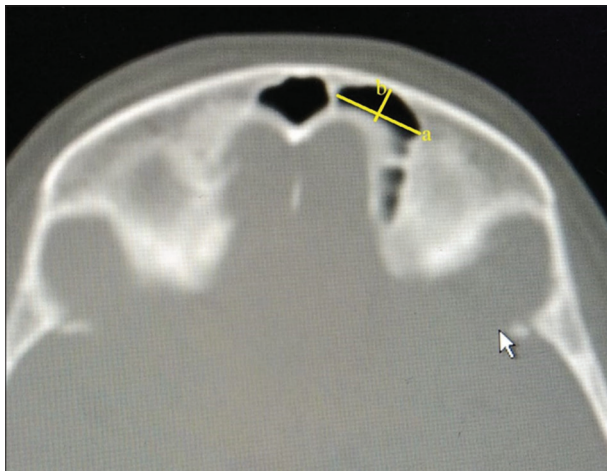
Axial computed tomography showing the frontal sinus width (a) and frontal sinus depth (b)
